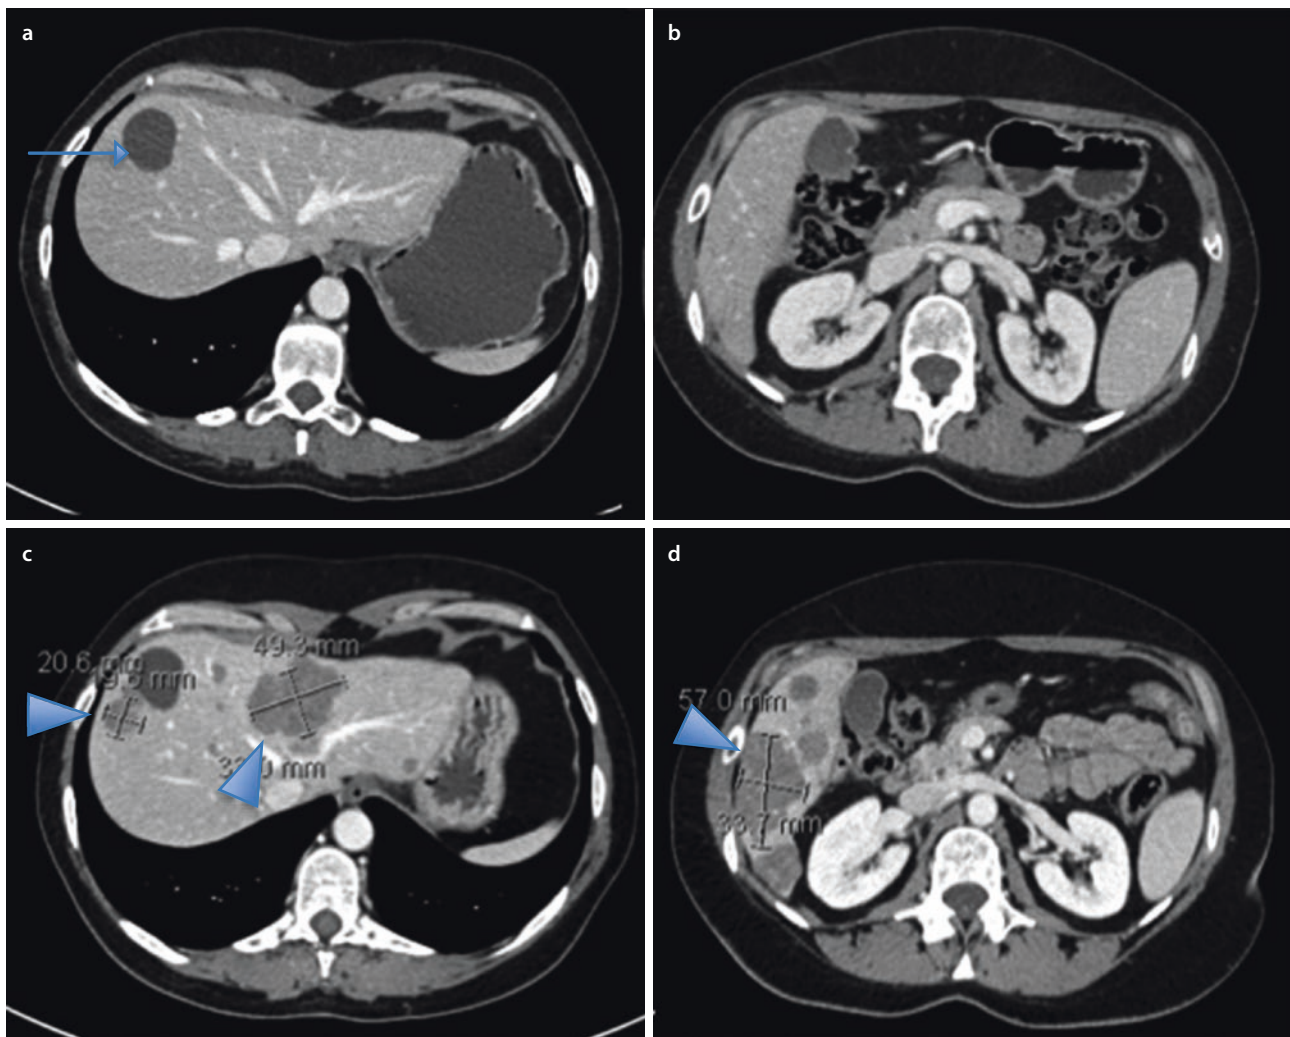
A young woman with breast cancer and progressive disease according to RECIST criteria. The first CT scan showed only hepatic cysts (arrow in a). Appearance of liver metastases in the same patient after a few months (arrowheads in c–d)
